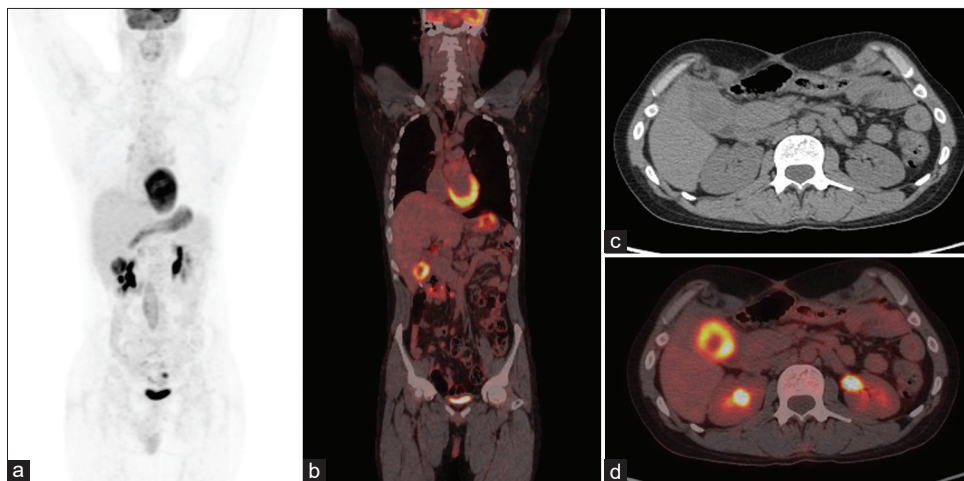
Case of 36-year-old male who was a postoperative follow-up case of adenocarcinoma colon. The patient had a suspicious mass in the region of hepatic flexure in ultrasound examination and was referred for re-staging Positron emission tomography/computed tomography (MIP [a], Coronal Positron emission tomography/computed tomography [b], Axial computed tomography [c] and Axial Positron emission tomography/computed tomography [d]). Positron emission tomography/computed tomography showed a FDG avid mass involving the hepatic flexure, in close relation to but not involving the liver (b-d). What was more important that identification of recurrence was absence of metastatic disease in Positron emission tomography/computed tomography (a). This made the patient eligible for re-surgery
